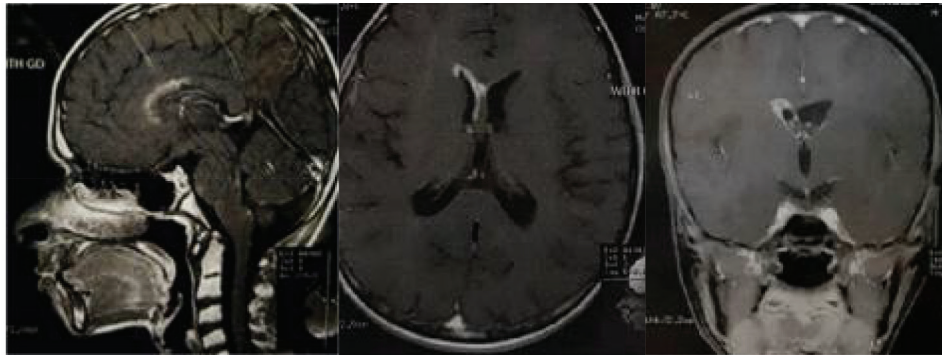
MRI images show multiple signal abnormalities ( Iso-signal on T1 weighted in figure A and high signal on flair T2 weighted in figure B and C ) involving Right ventricle wall and splenium , fourth ventricle floor and roof , and cerebellar tonsil with intense enhancement on post contrast images, respectively. (D1,D2 and D3)
